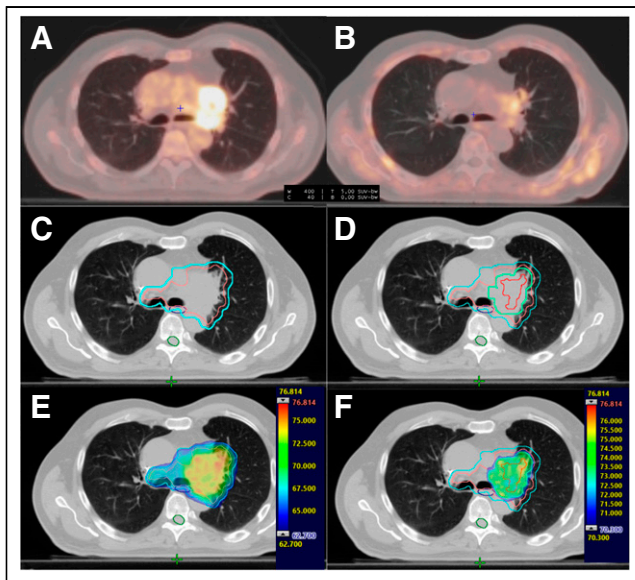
Example of radiotherapy planning based on FDG PET. (A) Initial planning PET/CT. (B) Planning PET/CT at 42 Gy. (C) Target volume: clinical target volume at 66 Gy with pink line and planning target volume at 66 Gy with light blue line and organs at risk. Esophagus with dark blue line and spinal cord with dark green. (D) Biologic target volume with red line and planning target volume at 74 Gy with light green line and same organs at risk as (C). (E) Initial dosimetry at 66 Gy with visible dose above 95% of prescribed dose (62.7 Gy) and same volumes as (C). (F) Dosimetry at 74 Gy with visible dose above 95% of prescribed dose (70.3 Gy) and same volumes as (D).
